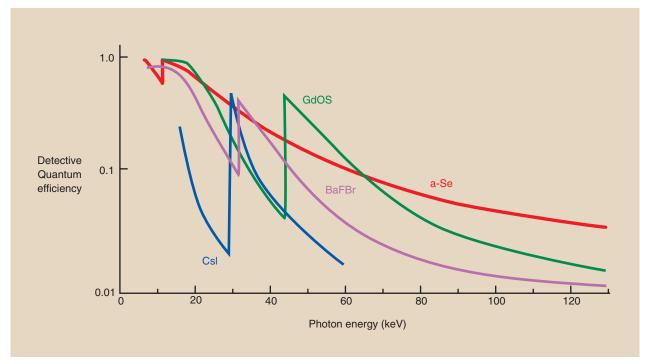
Detective quantum efficiency as a function of x-ray energy for various image receptor capture elements.
